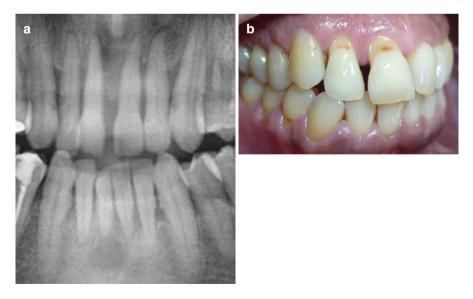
(a) Radiographic appearance of the diastema in patients with periodontal problems, (b) clinical appearance of the diastema in adult patient due to periodontitis
